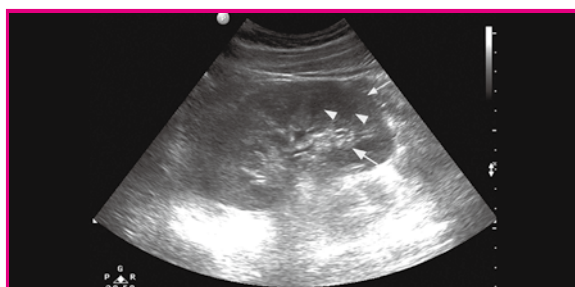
A grey scale ultrasound image shows a coronal scan of a normal kidney. The renal cortex (small arrow), medullary pyramids (arrowheads) and sinus echo complex (large arrow) of the kidney are demonstrated. (Personal collection)
